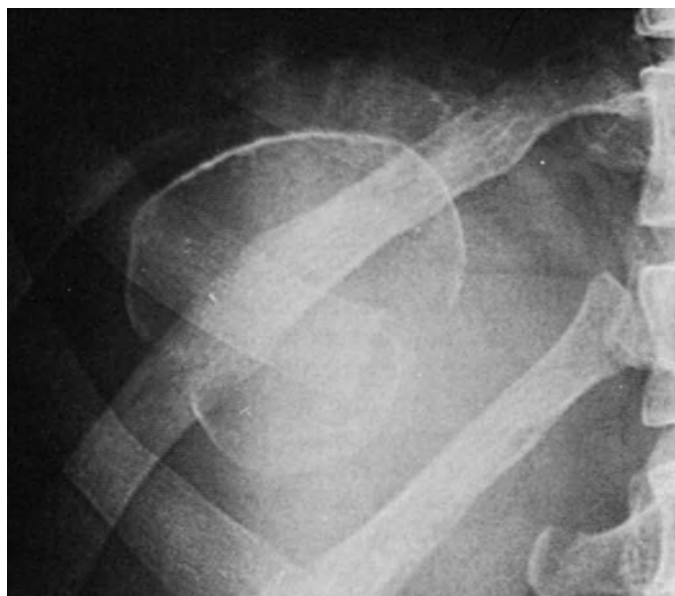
Hydatid cyst: plain radiographic findings. Curvilinear calcification of the pericyst is present in 20% to 30% of abdominal radiographs in patients with hydatid cysts.
